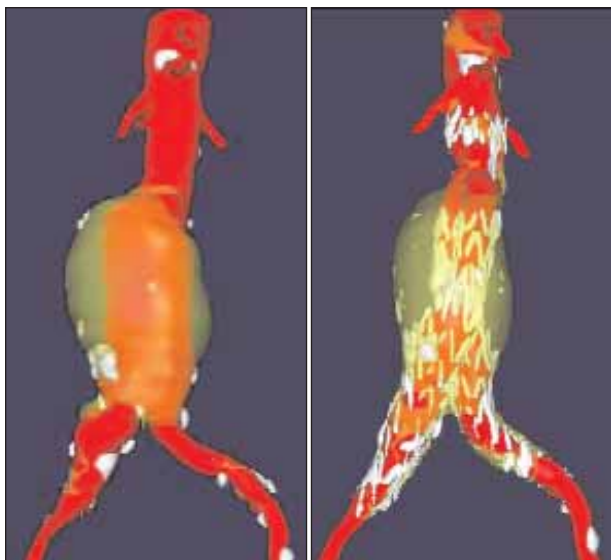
3D CT reconstructions of preoperative and 1-year postoperative imaging for patient 002.
